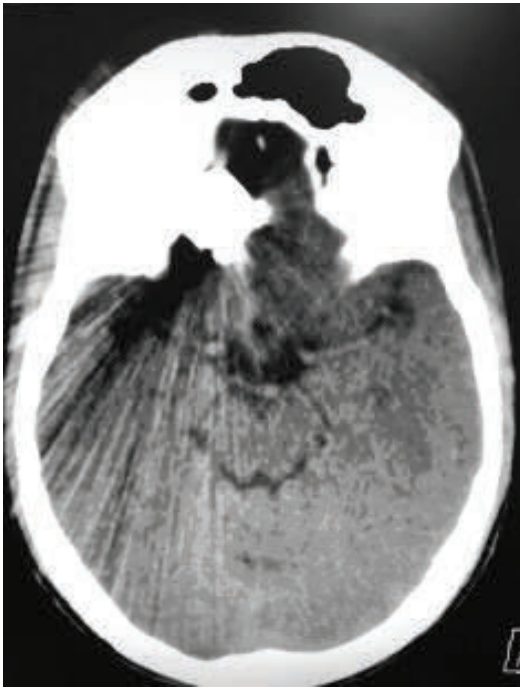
Preoperative roentgenogram image showing the foreign body impacted in the orbital roof.
